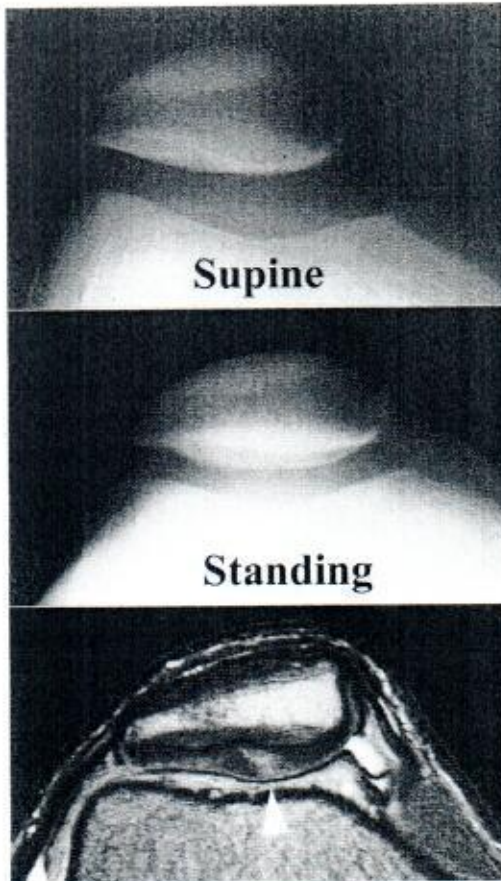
Axial radiographic views of the patellofemoral joint in a 19-year-old male with anterior knee pain and patellar instability, obtained in the supine and standing positions. Proton fat-saturated MR imaging demonstrated localized cartilage edema (arrowhead). The patient was a candidate for lateral release until the standing radiographic view demonstrated a normal position of the patella. Notice edema in the bone marrow of the patella. The patient was free of pain after surgical fenestration
